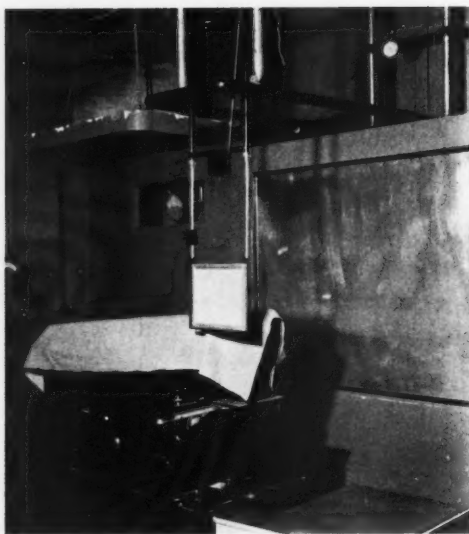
This home-made shock-proof bi-plane fluoroscope was built by the author and his Research Engineer, Mr. O. C. Hollstein, for the Chevalier Jackson Bronchoscopic Clinic. The tube for the horizontal ray is behind a partition. The ray comes through the aluminum panel. The target-screen distance is 4 feet. The tube and screen move together, being mounted on the same framework. In a later model which we recently built for another hospital, the oil-immersed vertical-ray unit was replaced by a Metalix tube mounted beneath the floor. We believe that in many instances the future will see X-ray tubes mounted beneath floors, behind walls, and above ceilings.
